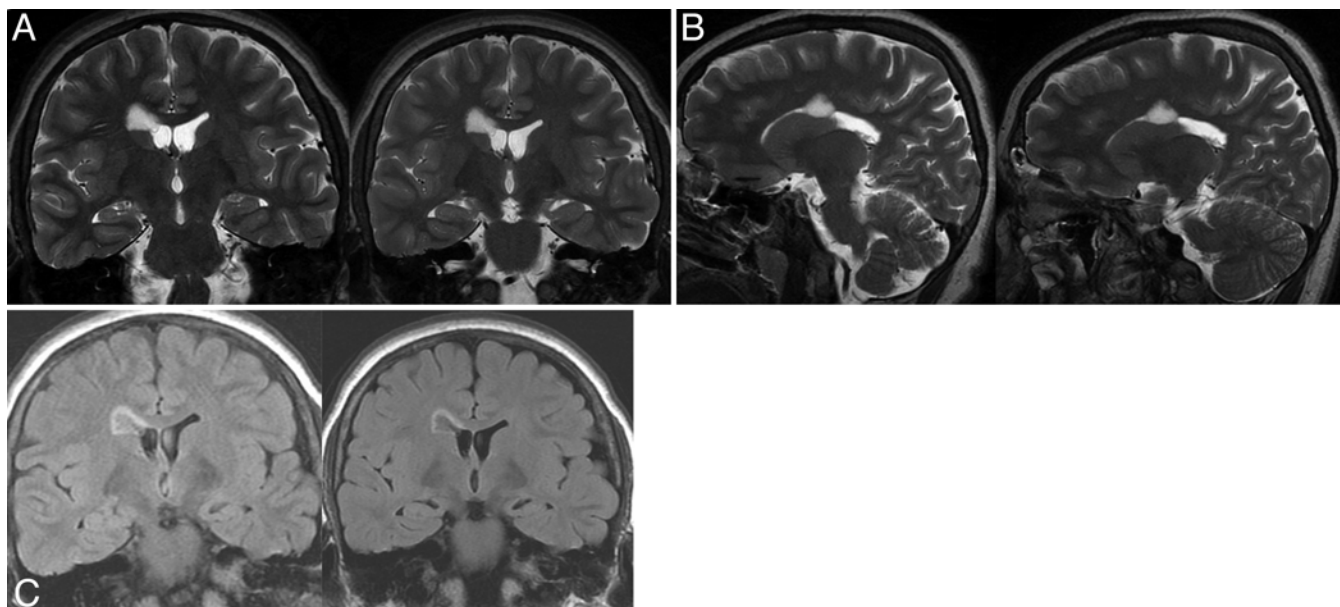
Case 13. Incidental ventricular mass lesion (assumed diagnosis of neurocytoma) found in a 13-year-old boy. Neuroimaging was performed as part of a research protocol for cardiac malformations. Coronal (A) and parasagittal (B) T2-weighted MR and coronal FLAIR (C) images. Left panels were obtained initially. Right panels show the lesion after a period of 6 months of wait-and-see.
